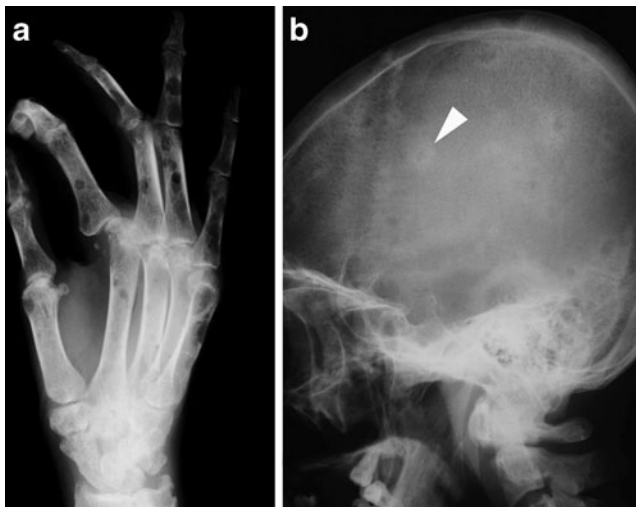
A 33-year-old man, the same patient of Fig. 2. a Before treatment multiple "punched-out" osteolytic lesions in metacarpals and phalanges and articular misalignment of the second metacarpophalangeal joint. b Sparse osteolytic lesions in the cranial vault. Reactive bone sclerosis was present surrounding the cranial lesions (arrow) in this radiography obtained during treatment (arrowhead)
